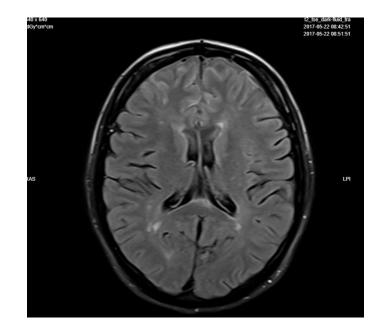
10 MRI in sagittal and axial plane, kindly permitted by Vilnius university hospital radiologic unit 2017
